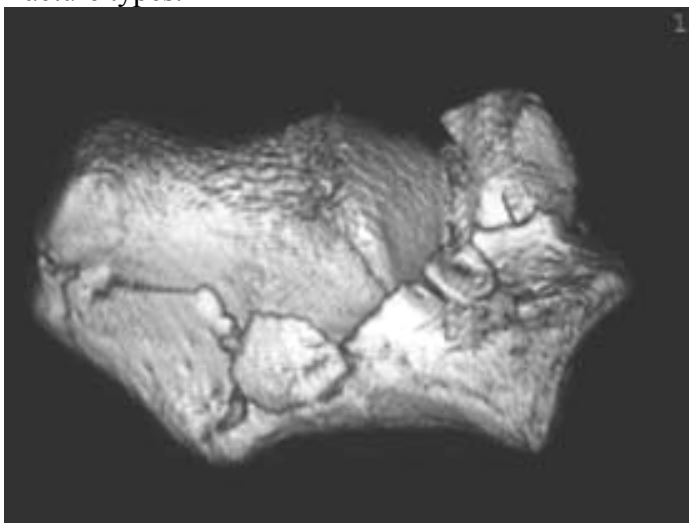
3D-CT showing vertical depression:
